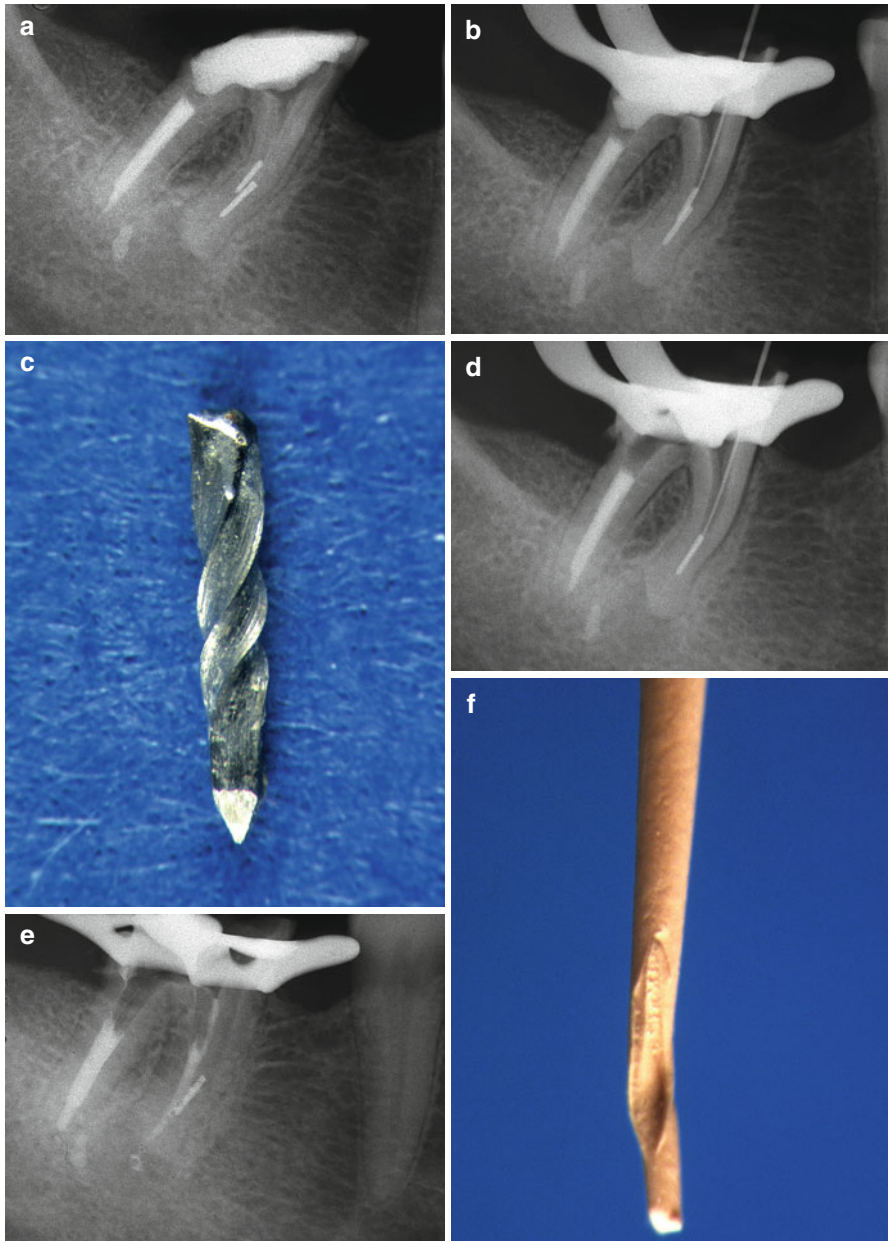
(a) Two broken instruments are present in the mesial root of this lower second molar. (b) A #10 K file is bypassing the broken instrument in the mesiolingual canal. (c) Just enlarging the canal around, the fragment has been removed from the mesiolingual canal. (d) A #10 K file is now bypassing the broken instrument in the mesiobuccal canal. (e) A gutta-percha point has been inserted in the mesiolingual, and then the K-file has been introduced in the mesiobuccal, to detect if the canals are joining together: the impression left on the gutta-percha from the file is confirming that the two canals have a common foramen; therefore, it is useless trying to remove the second fragment from the mesiobuccal canal. (f) The gutta-percha is condensed in the mesiolingual canal and now is in contact with the broken instrument in the other canal. (g) Postoperative radiograph. (h) 2-year recall
